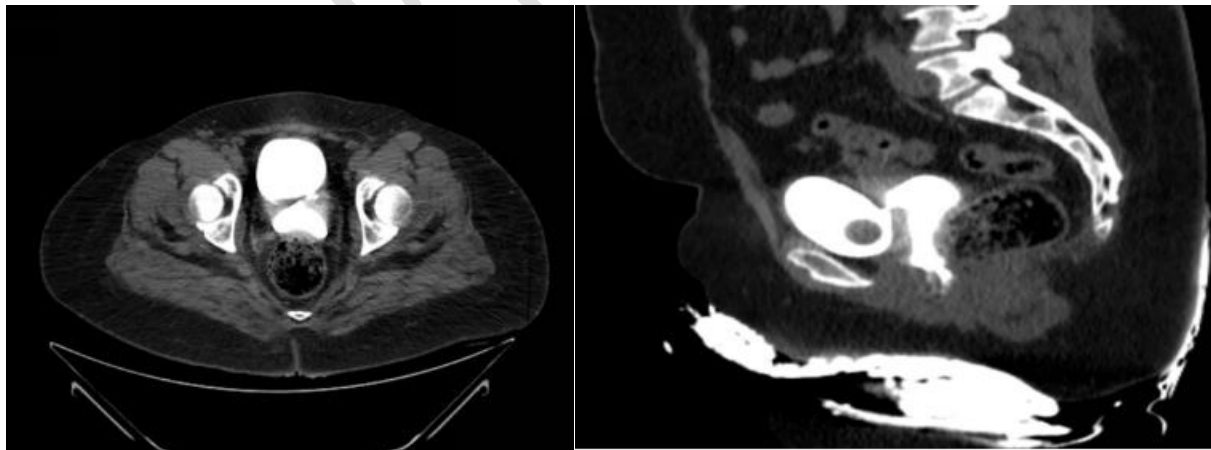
A: Axial CT cystogram image of the pelvis demonstrating the fistulous tract between the posterior urinary bladder and the vaginal vault with contrast both in the urinary bladder and vagina
